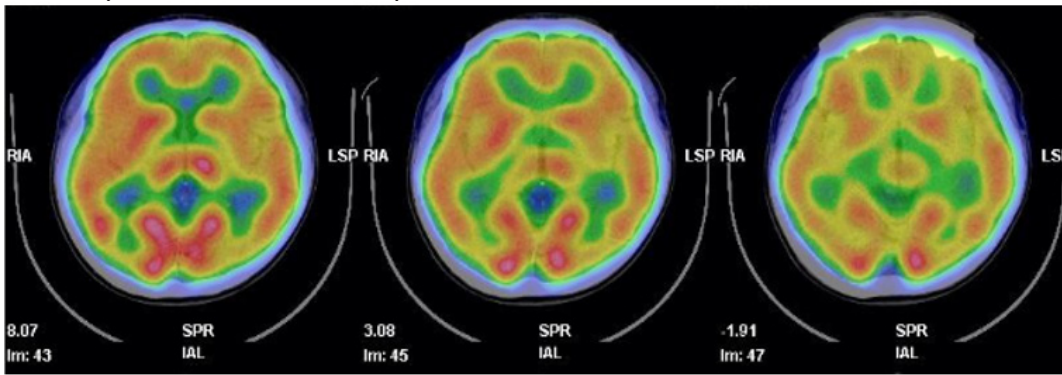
Axial view of SPECT-CT Scan.(1a, 1b) The SPECT-CT shows the continuous transverse view from head to feet, finding inhomogeneous uptake of the cerebral cortex with mildly decreased uptake over the left frontal and parietal lobes.
